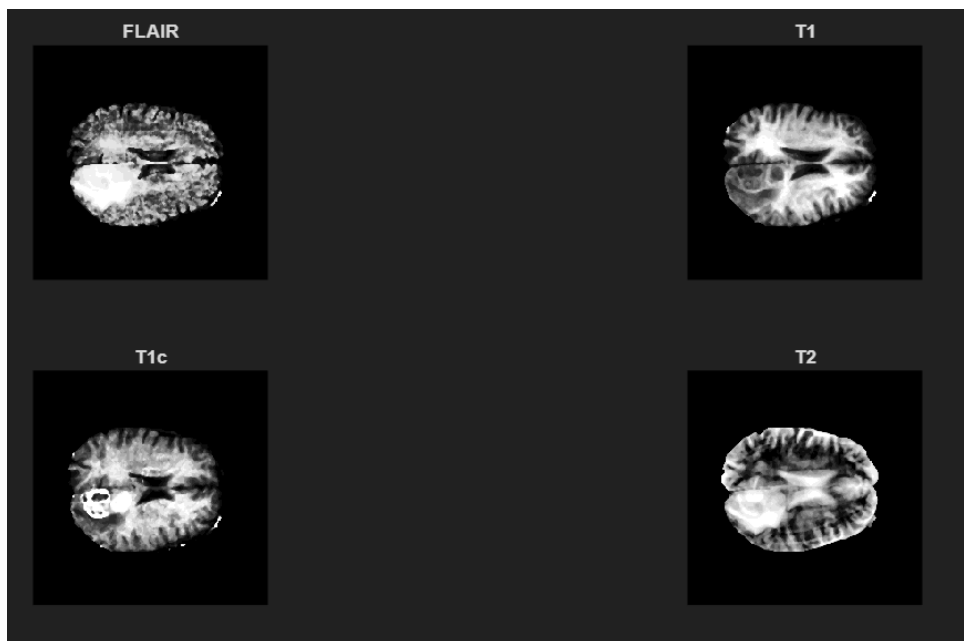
Example of the four MRI acquisition modalities (FLAIR, T1, T1c, T2) present in the Medical Decathlon dataset.
